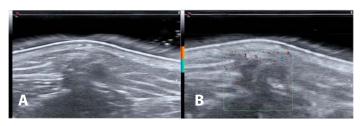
Ultrasound image of the patient with a high-frequency (6-18 MHz) linear transducer. A) Disruption of the fascia and protrusion of a hypoechoic structure into the subcutaneous fat. B) Power Doppler mode ultrasound image showing no increased vascularity.
